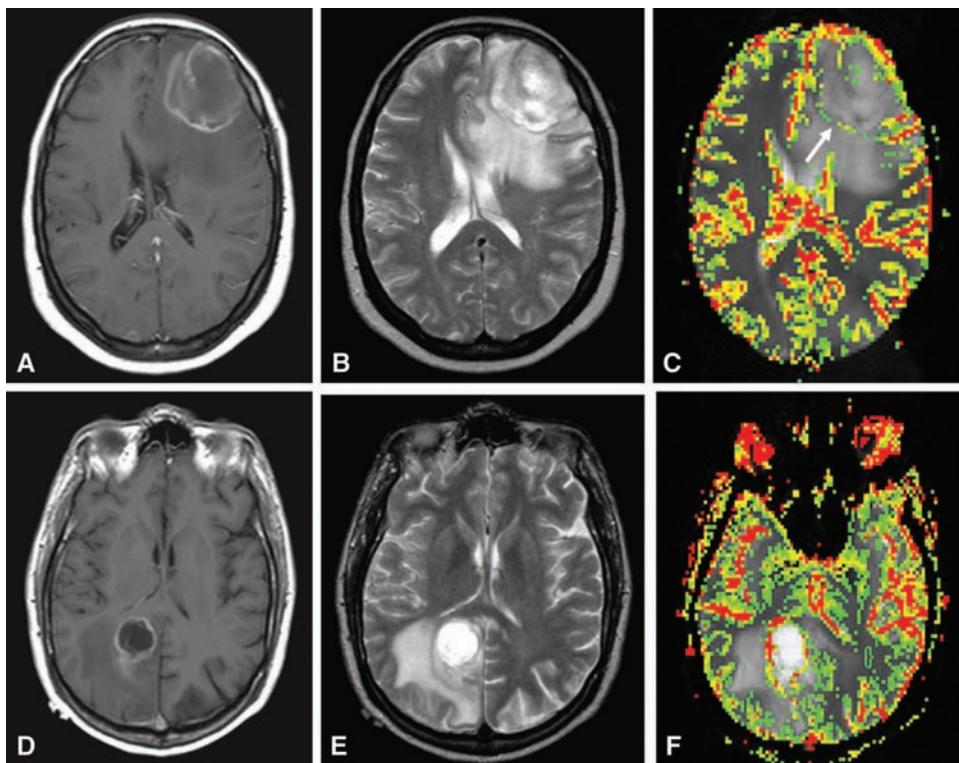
A 40-year-old woman with a metastasis from a lung carcinoma in the left frontal region. (A) Axial T1-weighted image postgadolinium shows a peripherally enhancing mass in the left frontal region with mass effect. (B) Axial T2-weighted image demonstrates moderate edema with questionable involvement of the corpus callosal genu seen more typically with infiltrating primary gliomas. Conventional MRI may sometimes be nonspecific in the setting of a solitary metastasis. (C) Gradient-echo axial DSC MRI with rCBV color overlay map demonstrates some increase in perfusion at the rim of enhancement (arrow); however, there is hypovascularity in the peritumoral region suggesting vasogenic edema without infiltrating tumor. (D) A 54-year-old man with a glioblastoma multiforme in the right mesial occipital lobe. Axial T1-weighted image postgadolinium shows a ring-enhancing mass with central necrosis. (E) Axial T2-weighted image demonstrates moderate edema with questionable involvement of the splenium of the corpus callosum. (F) Gradient-echo axial DSC MRI with rCBV color overlay map demonstrates increase in perfusion at enhancing tumoral as well as peritumoral regions, suggesting hypervascularity in the peritumoral region in keeping with infiltrating primary high-grade glioma. Abbreviations: DSC MRI, dynamic susceptibility contrast MRI; rCBV, relative cerebral blood volume. Source: From Ref. 80.
